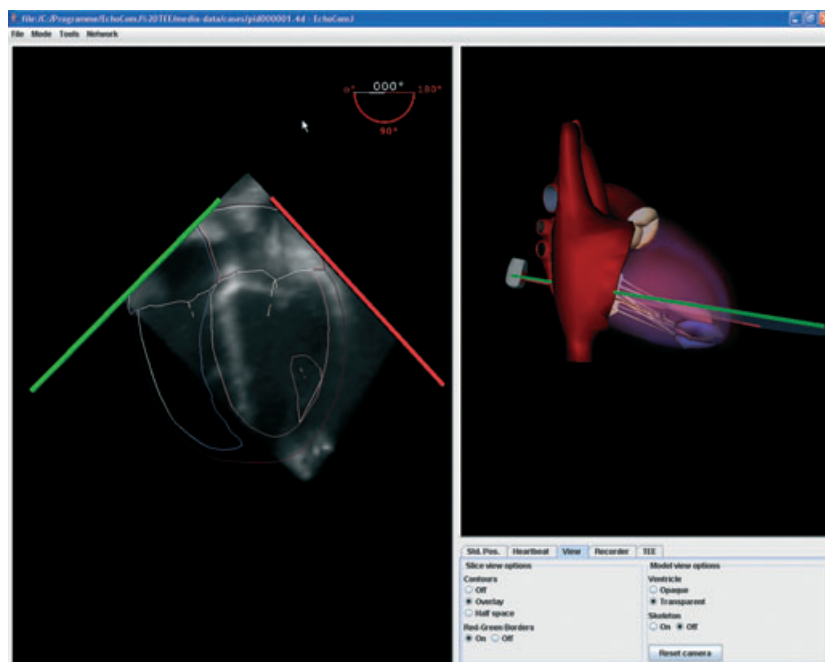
Screenshot of EchoComTEE. Visualised in the virtual scene (right window) are the heart, image plane and probe in a lateral projection. Visualised in the left window is the corresponding echocardiographic image, in this example a four chamber view. The contours of the heart model that are intersected by the virtual scan plane are optionally projected upon the echocardiogram to simplify identification of the structures. At the top the degree of rotation of the image plane is indicated. On the bottom right is a control panel with different menus, e.g. to control the heart rate or for different visualisation modes. The heart can be tilted, rotated or zoomed.
